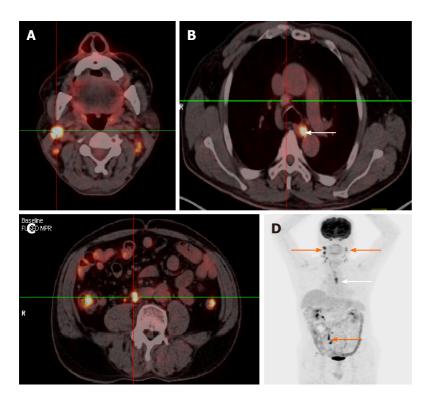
Fluorine-18-deoxyglucose positron emission tomography-computed tomography fused transaxial images (A-C) and maximum intensity projection (D). A and C: They show the uptake nodal focus (center of crossing); B: It shows an enlarged lymph node (center of crossing) and esophageal lesion (white arrow); D: It shows widespread lymph node involvement (orange arrows) and an esophageal lesion (white arrow).
